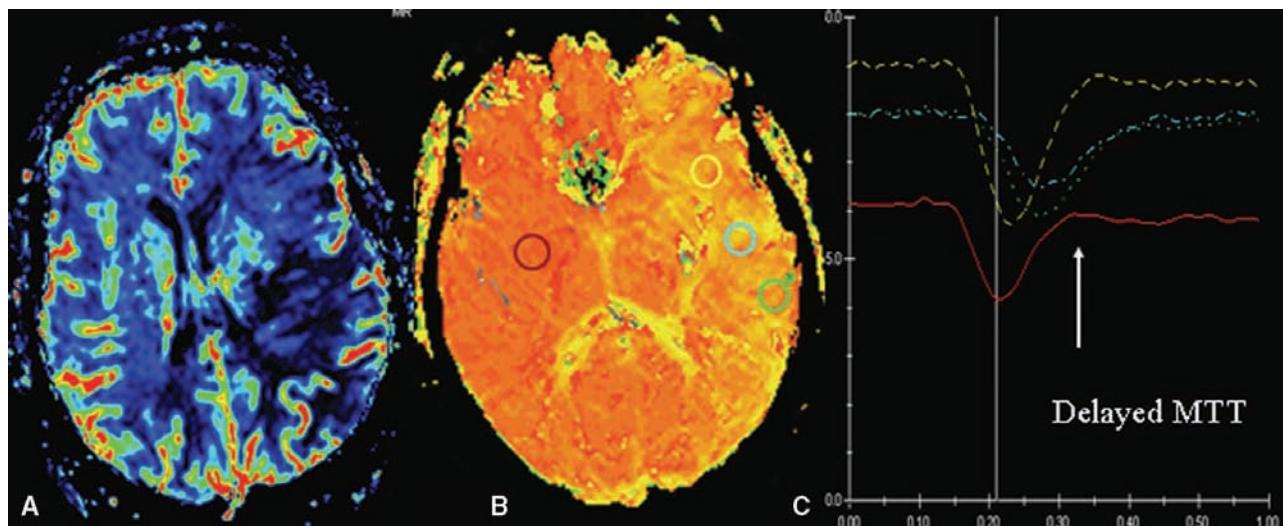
(A) Gradient-echo axial DSC MRI with CBF color overlay. (B) Gradient-echo axial DSC MRI with MTT color overlay maps demonstrating decreased CBF and prolongation in the MTT throughout the entire left MCA territory in keeping with left MCA ischemia. (C) Signal intensity versus time curves color coded to the four ROIs placed on the MTT maps, demonstrating prolongation in MTT in the green, blue, and to a lesser extent the yellow ROIs. The red ROI indicates normal MTT in the contralateral hemisphere. The prolonged MTT and reduced CBF in the MCA distribution are in keeping with an ischemic stroke. CBF and MTT are more specific than CBV in differentiating infarct from tumor. Abbreviations: DSC MRI, dynamic susceptibility contrast MRI; CBF, cerebral blood flow; MCA, middle cerebral artery; MTT, mean transit time; ROIs, regions of interest.
